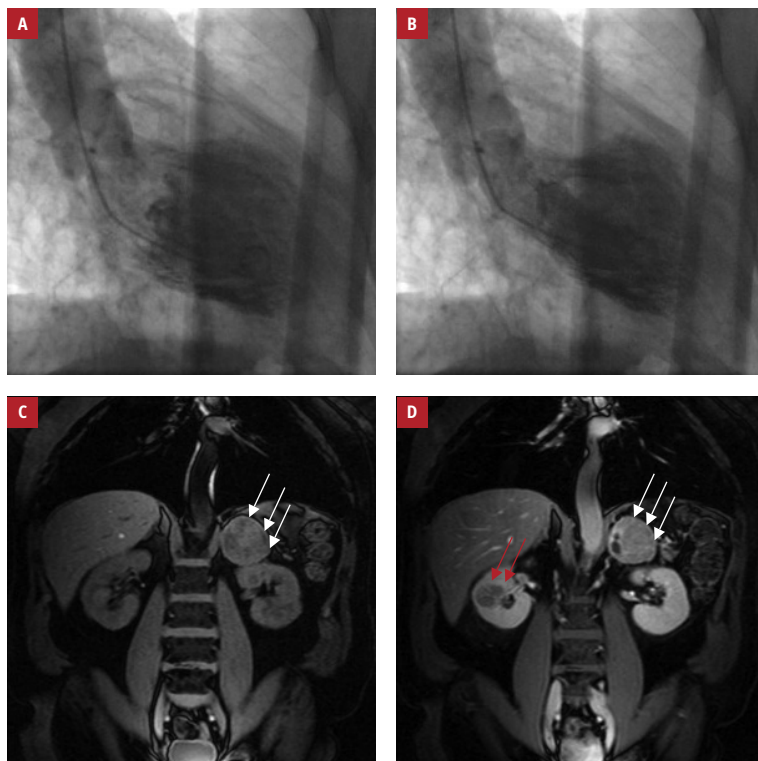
Imaging of a patient with pheochromocytoma and papillary renal cell carcinoma: A, B – left ventriculography showing systolic midventricular and apical dyskinesia with basal hypercontraction; C, D – abdominal magnetic resonance imaging revealing a large (5.6×5.3×5.3 cm), well-defined, heterogeneous mass in the left suprarenal area (white arrows) and an oval (3.6×2×3 cm), well-circumscribed, solid tumor with heterogeneous contrast enhancement in the hilar region of the right kidney (red arrows)
